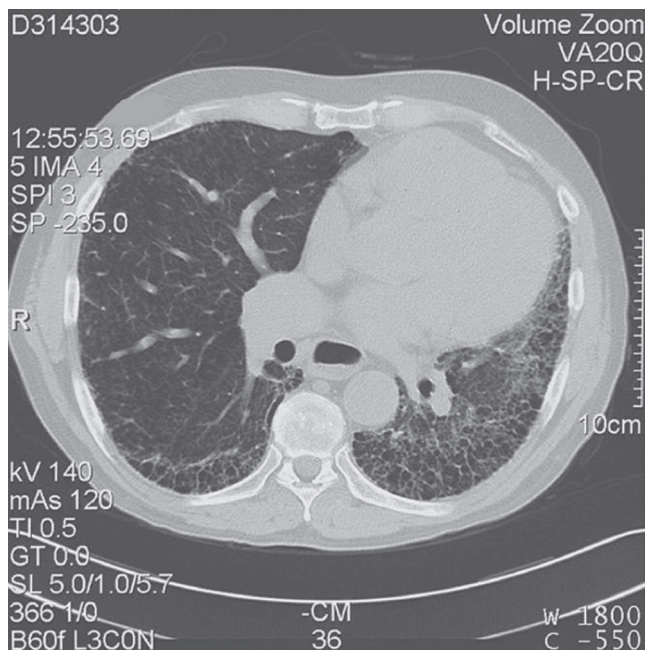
■ Axial computed tomographic image from a patient with idiopathic pulmonary fibrosis shows a markedly diminished left pleural space with the mediastinum shifted to the left. This finding mandates the use of cardiopulmonary bypass for adequate exposure.
